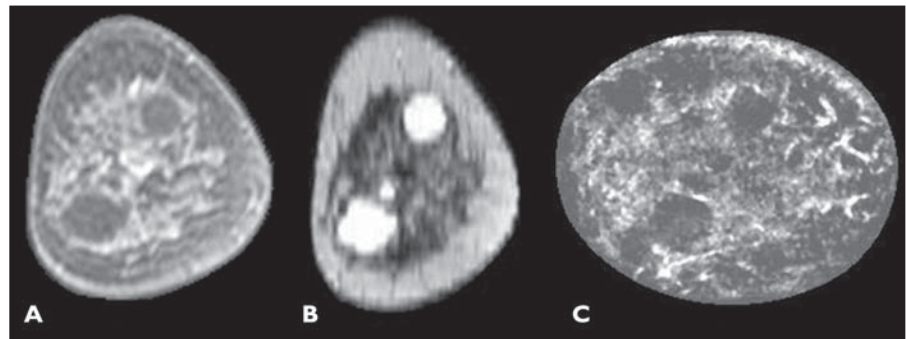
52-year-old woman with heterogeneously dense breasts. A, Two simple cysts in 1- and 7-o'clock positions are seen on coronal T1 fat-saturated enhanced MR image. B, Cysts have much better contrast on this T2 image than on A. C, Reflection ultrasound tomography image shows these simple cysts did not reach sound-speed thresholds or attenuation threshold for solid masses.
